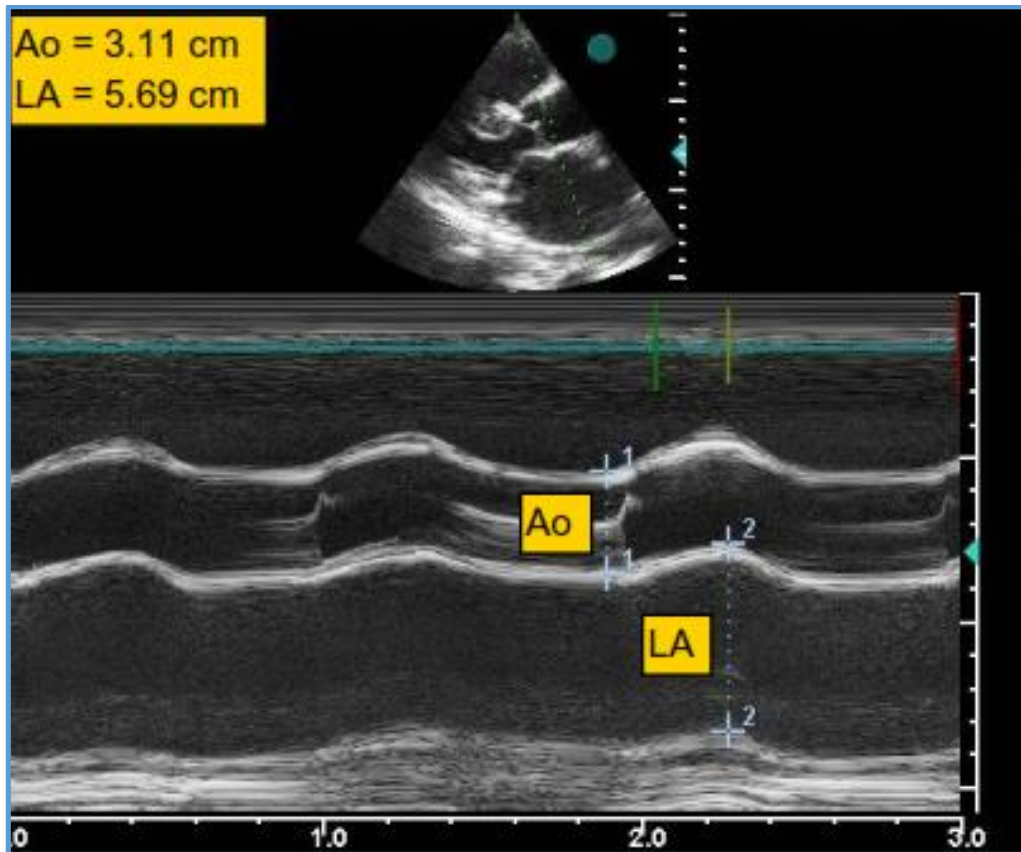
Echocardiography in a 30 years old patient positioned at 30° left lateral position
